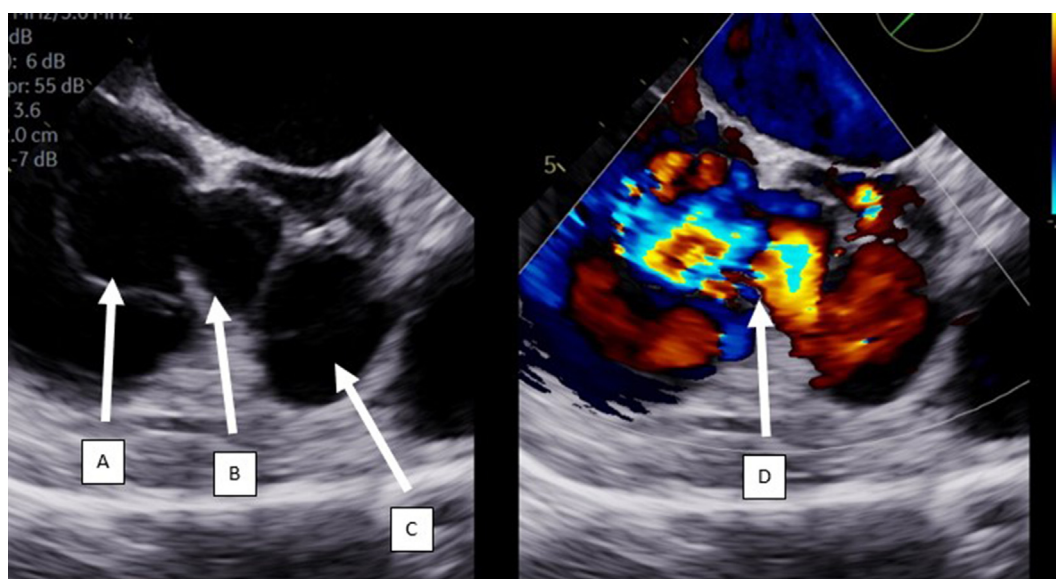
Left: Transesophageal echocardiogram short axis. Arrow A, sinus of Valsalva aneurysm, arrow B, left noncoronary cusp, arrow C, coronary cusp. Right: Transesophageal echocardiogram short axis with Doppler. Arrow D, sinus of Valsalva aneurysm. This view does not show rupture.
